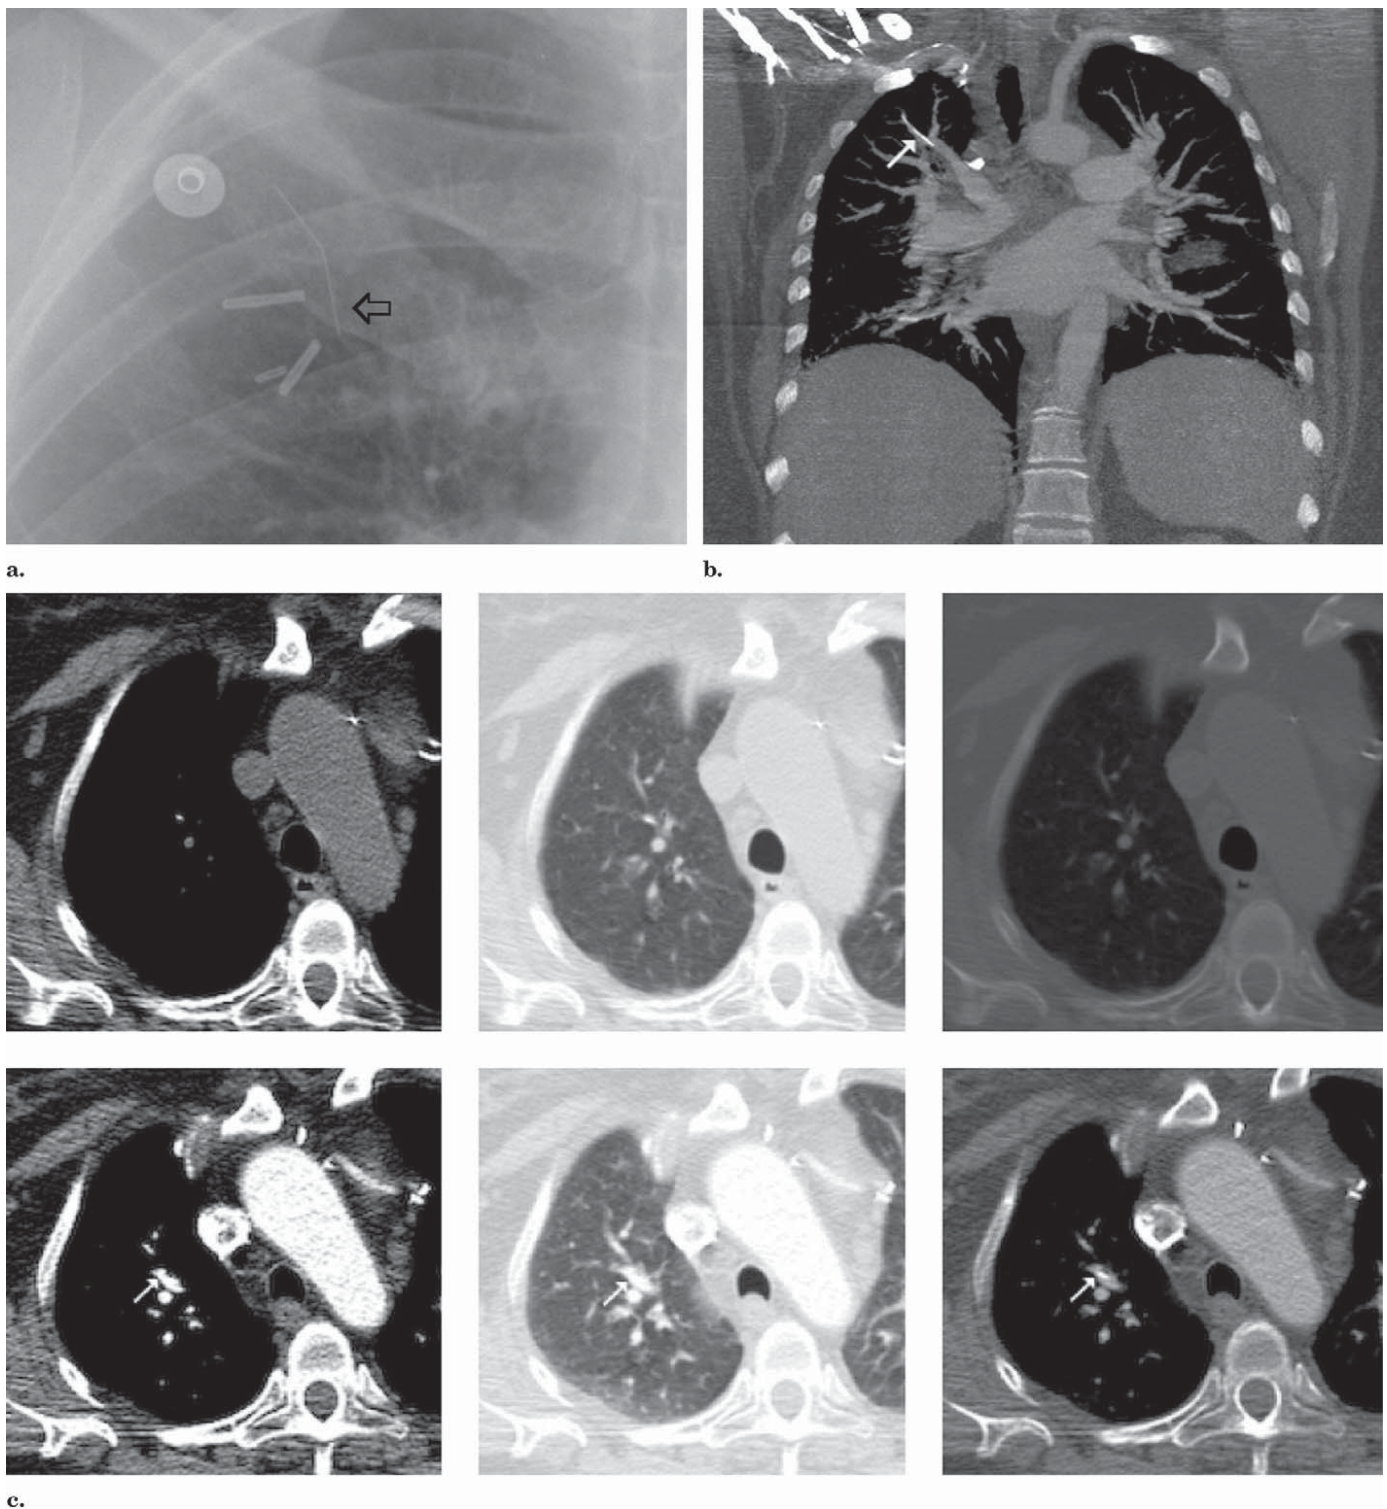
(a) Magnified view of right upper lobe (same as Fig 4). Migrated arm (open arrow) was missed on numerous chest radiographs and chest CT examinations over a period of 18 months. (b) Fragment in right upper lobe is seen on contrast-enhanced chest CT scan (white arrow). (c) Axial images with and without contrast medium windowed and leveled for mediastinum, lung, and bone, respectively. White arrow points to the hard-to-see filter fragment on the contrast images.
